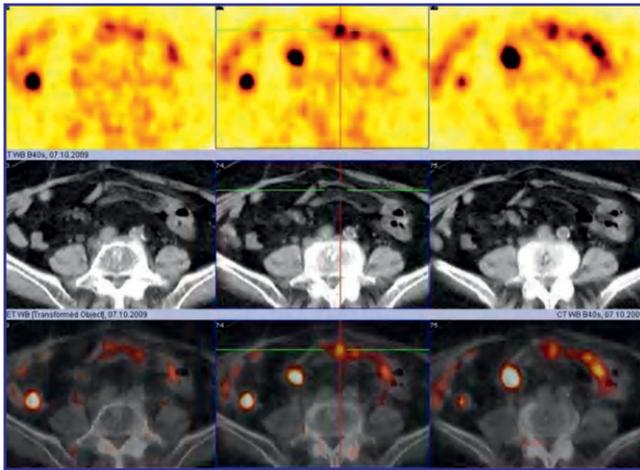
^{68}Ga -DOTATOC PET/CT somatostatin receptor imaging in a multifocal neuroendocrine tumor of the ileum. At least 13 subcentimeter foci were observed on PET/CT.
